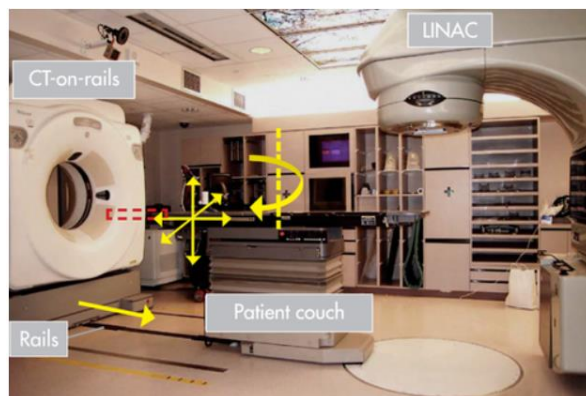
Computed tomography on rails and Linear accelerator system [72]
